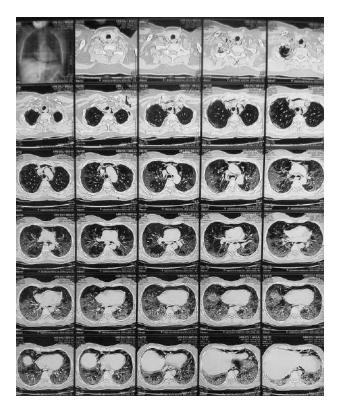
HRCT shows diffuse ground glass opacities, with bilateral consolidation
